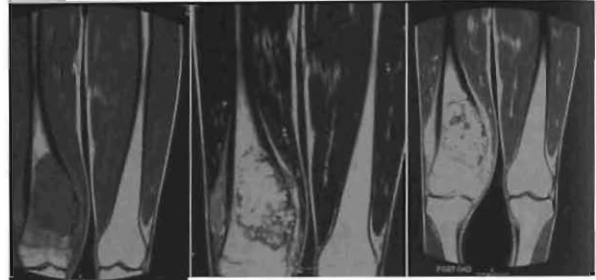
MRI images: T1WI, T2WI and post-Gadolinium T1WI.
